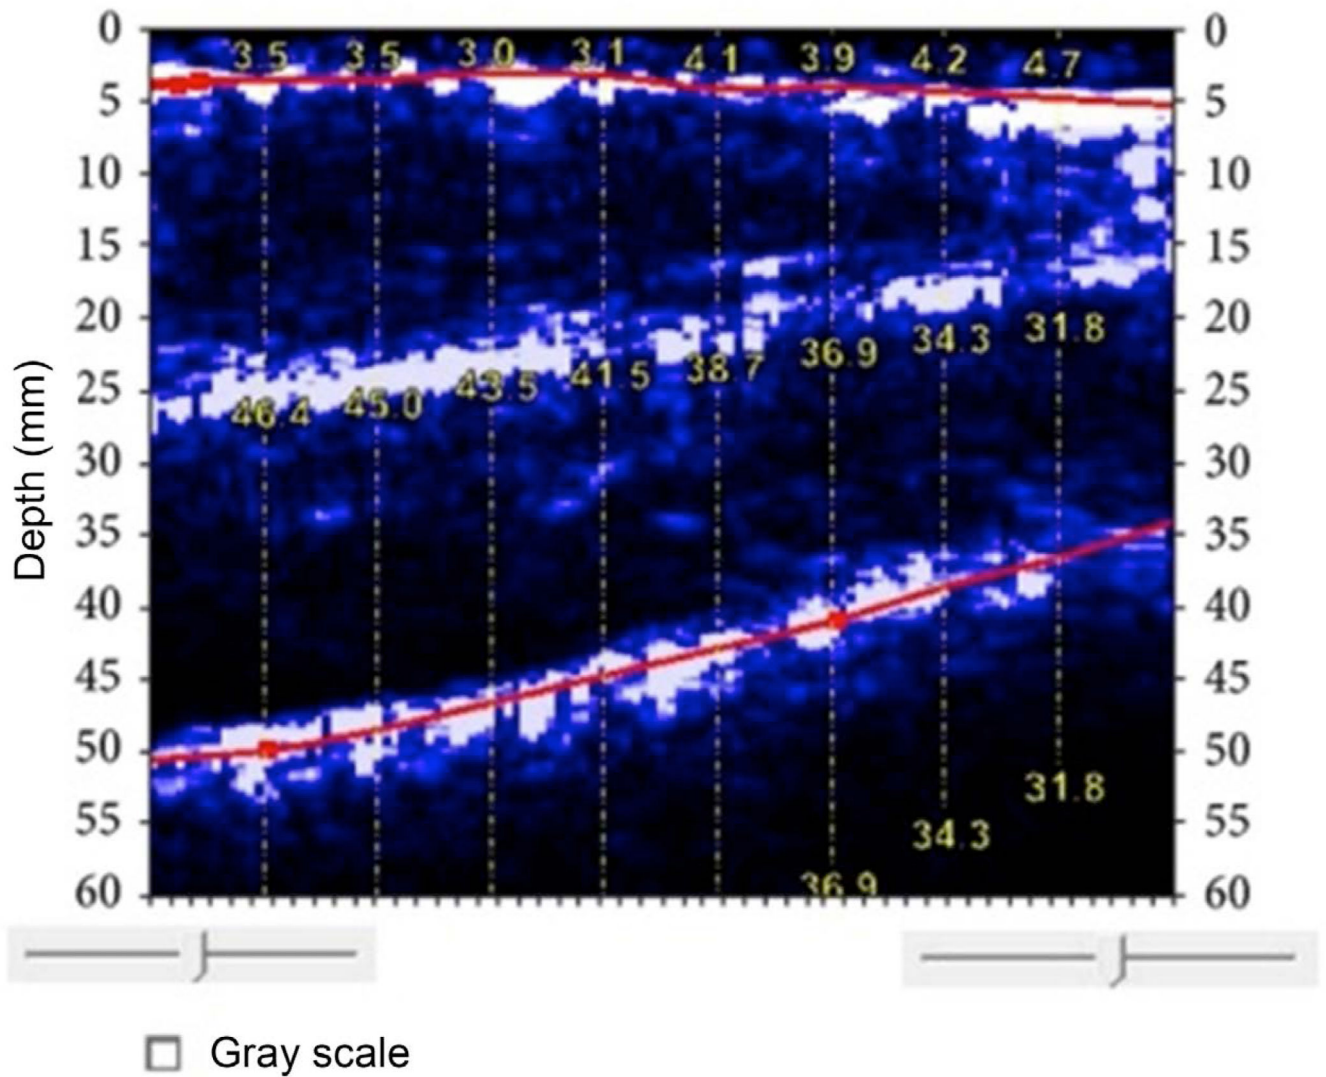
BodyMetric ultrasound image of thigh. The top line indicates the subcutaneous fat-muscle interface (average thickness of 3.69 mm). The bottom line indicates the muscle-bone boundary. The muscle thickness ranges from 32.0 mm to 46.6 mm. The white layer in the center is the boundary of the rectus femoris and vastus intermedius. (Reproduced from ref 12)
